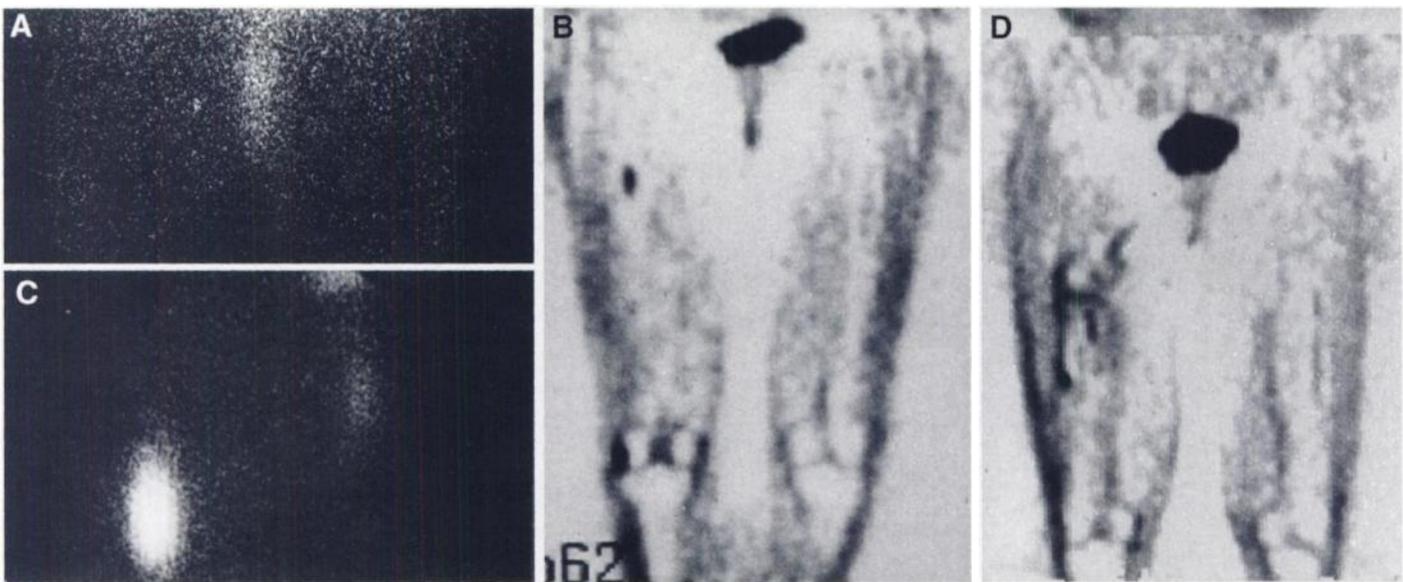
Bone metastasis in right femur was initially radioiodine negative. (A) Radioiodine scan of femur, anterior view, before treatment with retinoic acid; thyroid-stimulating hormone (TSH): 25 $\mu\text{U}/\text{ml}$; radioiodine amount: 1.1 GBq. Redifferentiation therapy induced distinct radioiodine uptake at this metastatic site. (C) Identical view as A after treatment with retinoic acid; TSH: 38 $\mu\text{U}/\text{ml}$; radioiodine amount: 11.1 GBq. Metastasis was FDG positive before treatment. (B) Coronal FDG PET slice, patient's left side is on the right, and PET scan after surgical removal showed only nonspecific tracer uptake in adjacent tissue of right thigh. (D) Identical slice as B after surgery.
